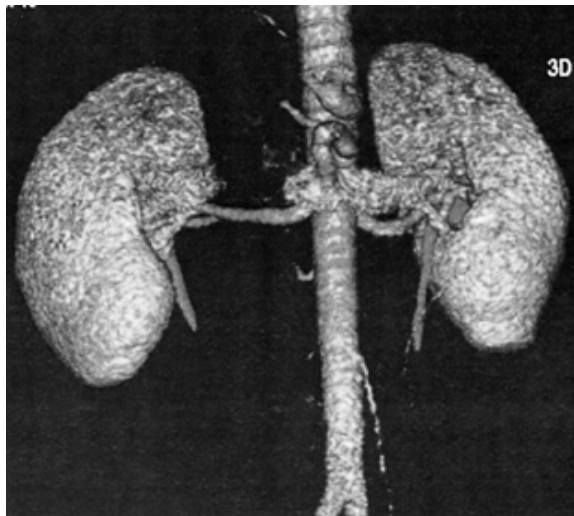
4. Living renal donor computed tomography angiogram shows single arteries to each kidney and left renal vein passing anterior to the aorta. Different color schemes can be used depending on the preference of the viewing physicians. See also Color Figure 3F.4.
